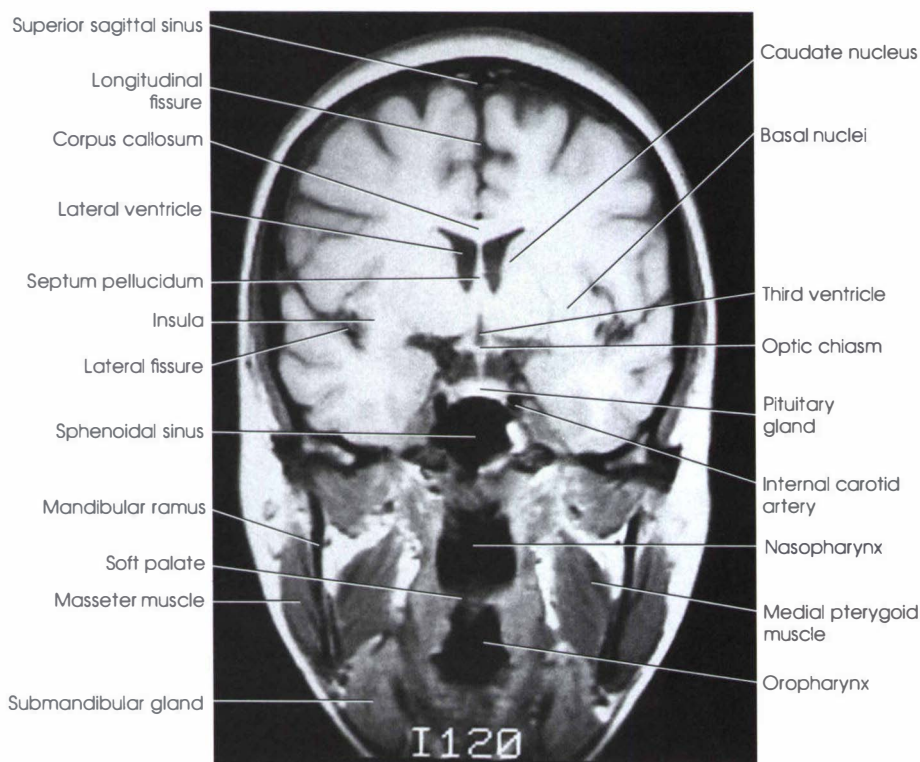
Coronal MRI corresponding to level A in Fig. 27-14.
